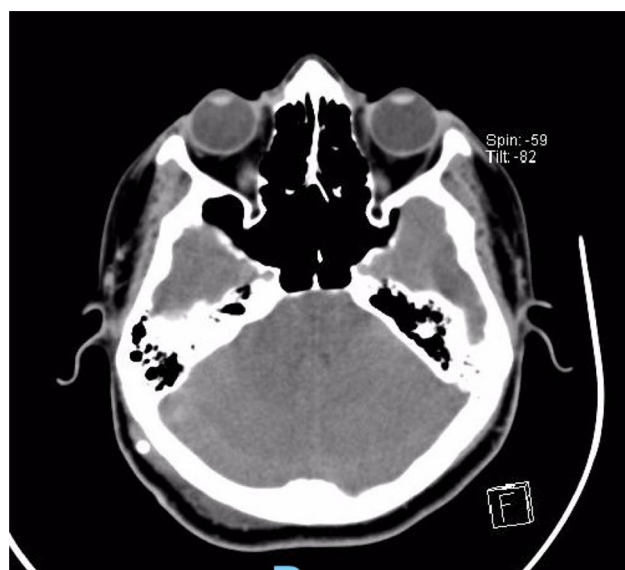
Routine immediate postoperative brain computed tomography showing that there was no spontaneous hyperdensity
